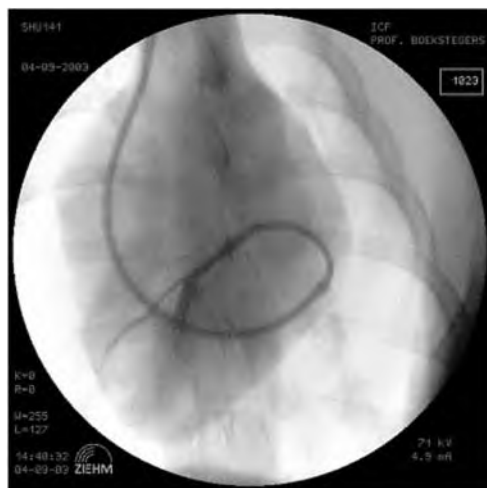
Angiogram of the anterior inferior cardiac vein after percutaneous ultrasound-guided venous VPASS™. Contrast agent is filling the distal AIV as well as the VSTENT™ which drains into the left ventricular cavity during diastole.
